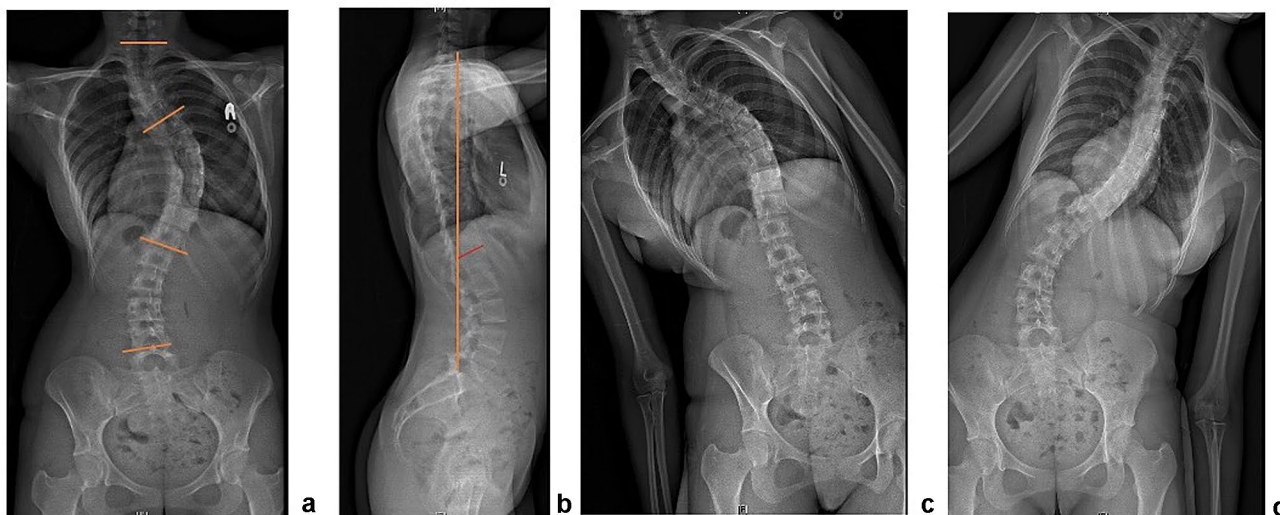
a Anteroposterior and b lateral pre-operative standing radiographs showing a proximal thoracic curve of 29.4° , main thoracic of 56.3° and thoracolumbar curve of 32.1° with normal sagittal balance. The pelvic incidence is 48° with an inflexion point at T12/L1 (indicated by the red line). c the Left bending radiograph showing a
